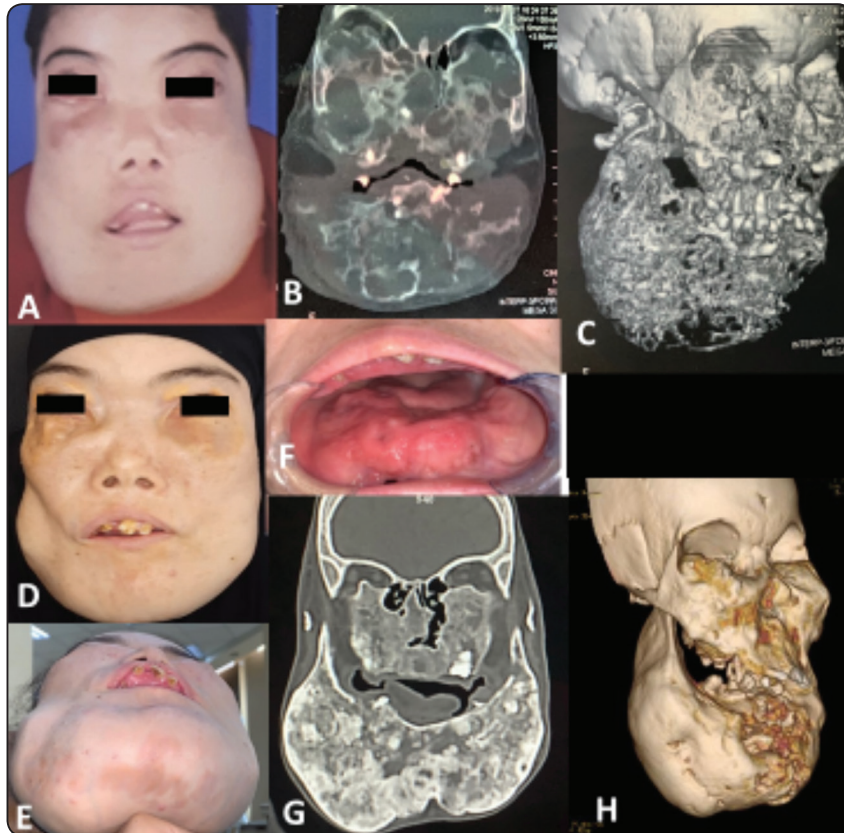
(A-H): (A) Clinical (B) Frontal CT (C) Reconstructed 3D-CT views of (patient 4) at age 14 showing bilateral mandibular swelling and eyes to heaven appearance. Multilocular radiolucent lesions extension and pressure erosion in both jaws' cortex and encroachment on orbital floor. (D, E) Clinical (F) Intraoral current views at age 24 showing persistent huge mandibular swelling, gingival hypertrophy, and backward tongue displacement. (G) Frontal CT (H) Reconstructed 3D-CT showing patchy sclerosis in large areas of both jaws, nearly complete reossification of outer cortex.
